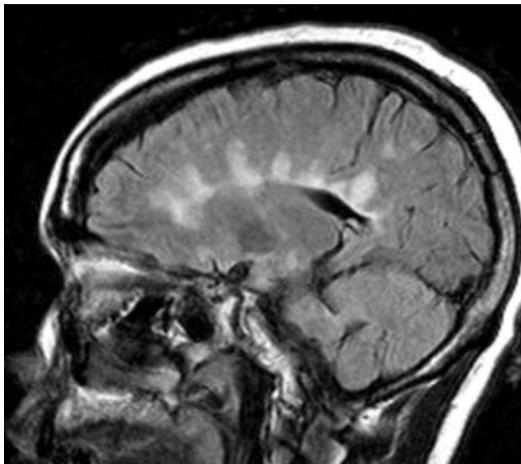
Sagittal fluid-attenuated inversion recovery (FLAIR) image demonstrates typical periventricular lesions so called, Dawson fingers.
